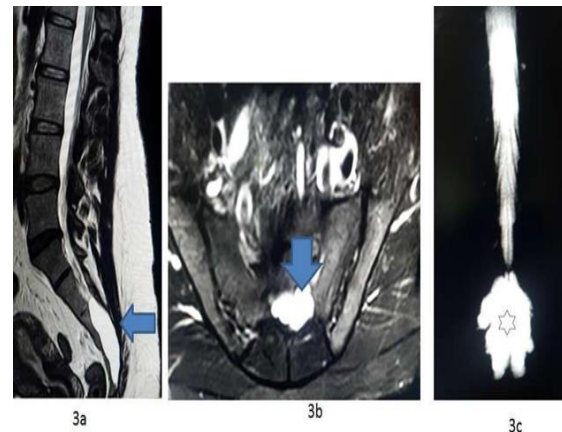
Case 3- MRI Lumbosacral spine of 36-years old female medical doctor with low backache and sexual dysfunction of increasing severity. (a) T2W Sagittal section shows a big vertically expanded hyperintense lesion against dorsal aspect of sacral vertebrae (horizontal blue arrow). (b) T2W axial section shows the expanded hyperintense lesion at mid sacral level (inverted blue arrow). (c) MR myelography shows multiple perineural cysts as finger like projections from the lower end of the cord (black star).
